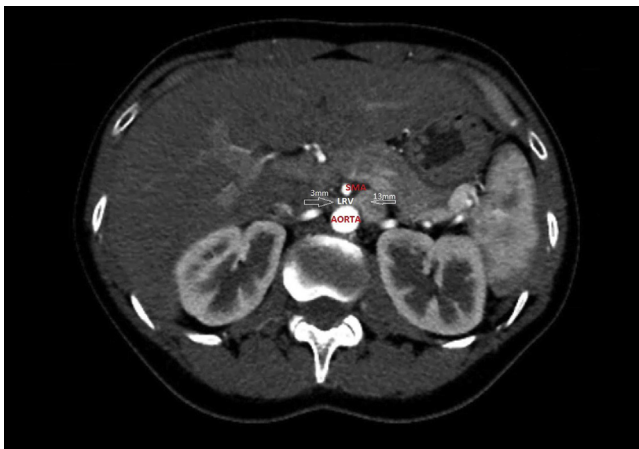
Computed tomogram of the abdomen, showing a change in the caliber of the left renal vein (LRV) as it passes between the superior mesenteric artery (SMA) and aorta.
